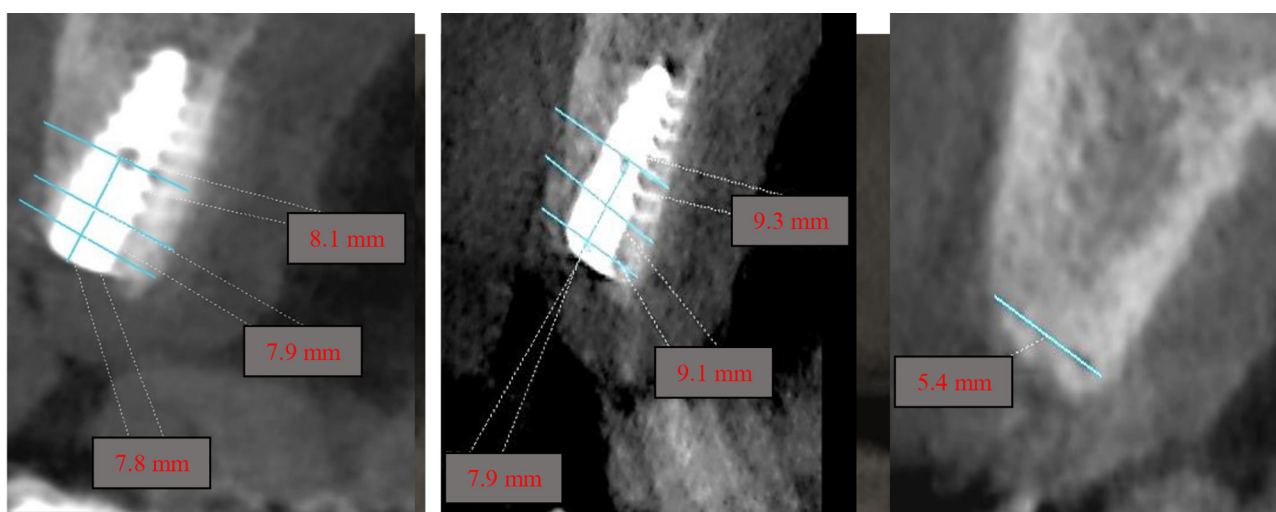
Radiographic evaluations to show the overall width at T0, T1, T2 times.
